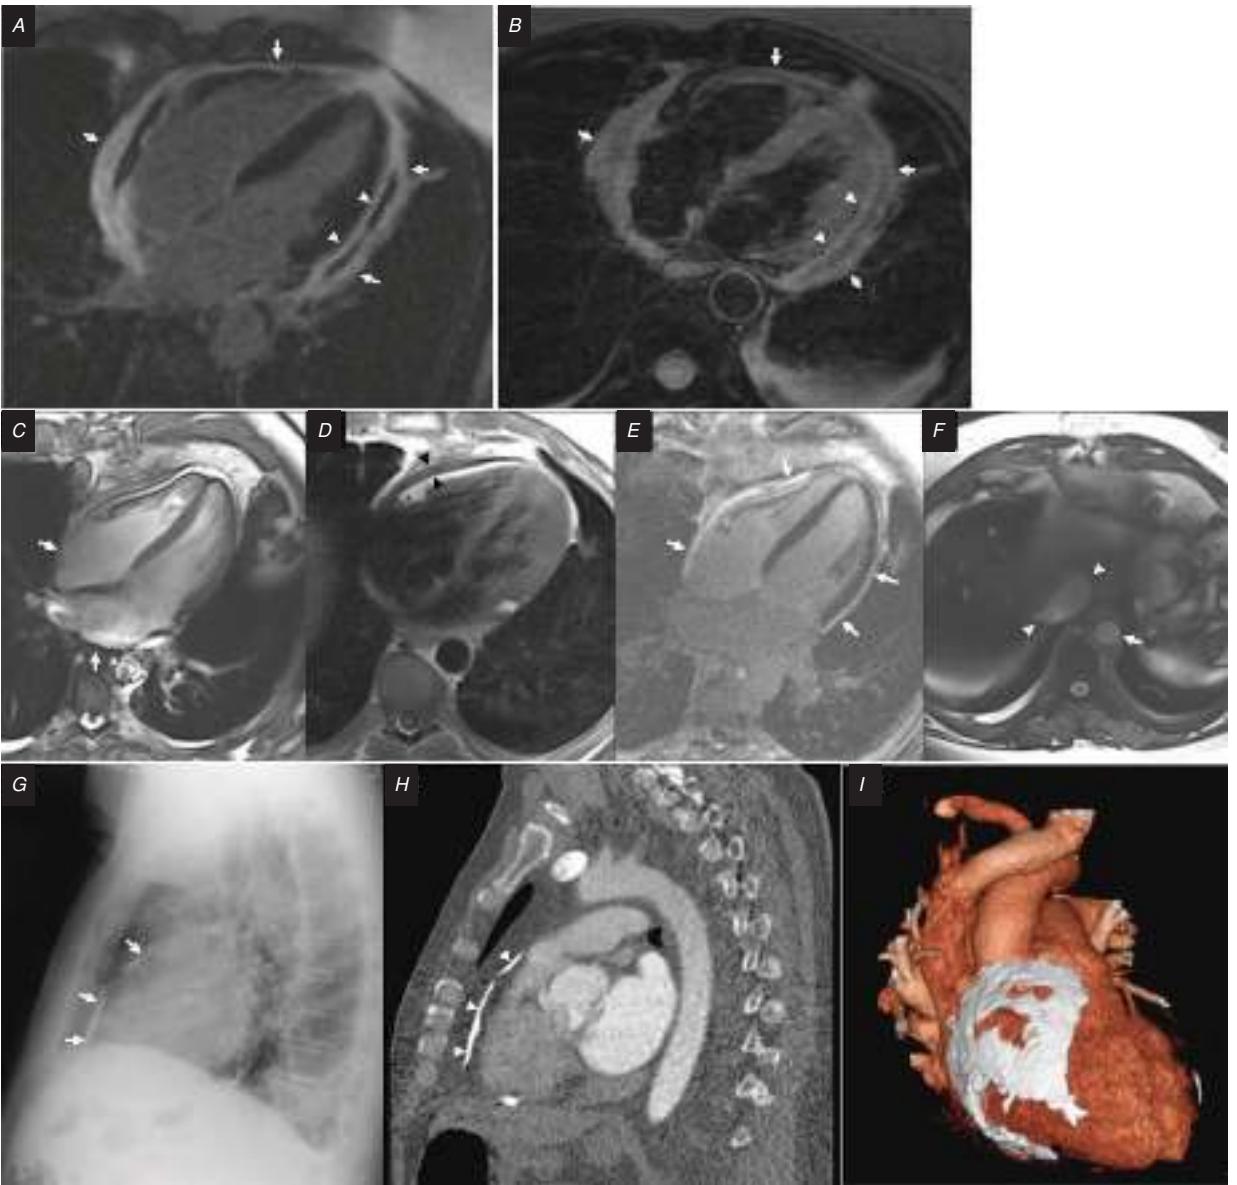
Representative cardiac magnetic resonance (CMR) and CT features of pericardial disease. *A*, Four-chamber late gadolinium enhanced image showing severe, diffuse enhancement of both the visceral (arrowheads) and parietal (arrows) layers of the pericardium. The black signal between the two layers represents effusion. *B*, Axial T2-weighted image showing severe thickening and increased signal of both the visceral (arrowheads) and parietal (arrows) layers of the pericardium. *C*, Four-chamber steady-state free precession (bright-blood) image in early diastole showing the apical interventricular septum bowed to the left (white arrowhead) due to the increased right-sided ventricular volume at the expense of the left ventricular volume. Dilated atria (white arrows) are also a feature of constriction. *D*, Axial T1-weighted double inversion recovery (black-blood) image showing increased thickness of the pericardium >4 mm (black arrowhead). *E*, Four-chamber late gadolinium enhanced image showing diffuse enhancement of the thickened pericardium (white arrows). *F*, Axial steady-state free precession (bright-blood) image showing dilated inferior vena cava (IVC) (white arrowheads), which is greater than twice the size of the normal aorta (white arrow). Under normal conditions, the IVC should be similar in size to the aorta. *G*, Lateral chest radiograph showing calcification of the pericardium anteriorly (arrows). *H*, Corresponding sagittal view from computed tomography angiography (CTA) showing the calcified pericardium (arrowheads). *I*, Three-dimensional rendered segmented image from the CTA showing the extent of the pericardial calcification. (Images courtesy of Dr. Michael Steigner, Brigham and Women's Hospital.)
